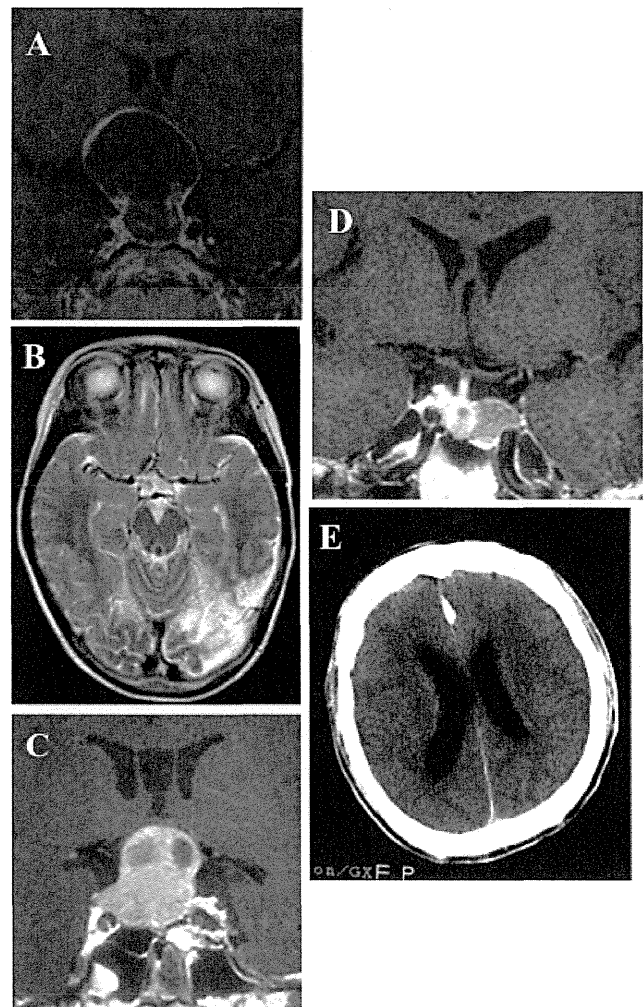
A, B: A 4-year-old boy with craniopharyngioma. A: Preoperative MR imaging (Gd-enhanced T₁WI) reveal a large, cystic, dumbbell-shaped tumor. B: T₂WI revealed left occipital infarction due to postoperative SPM. C: A 40-year-old man with non-functioning adenoma. D; E: A 55-year-old man with acromegaly. D: Preoperative MR imaging E: CT revealed brain edema due to SPM. CT: computed tomography, MR: magnetic imaging, SPM: *Streptococcus pneumoniae* meningoencephalitis.
